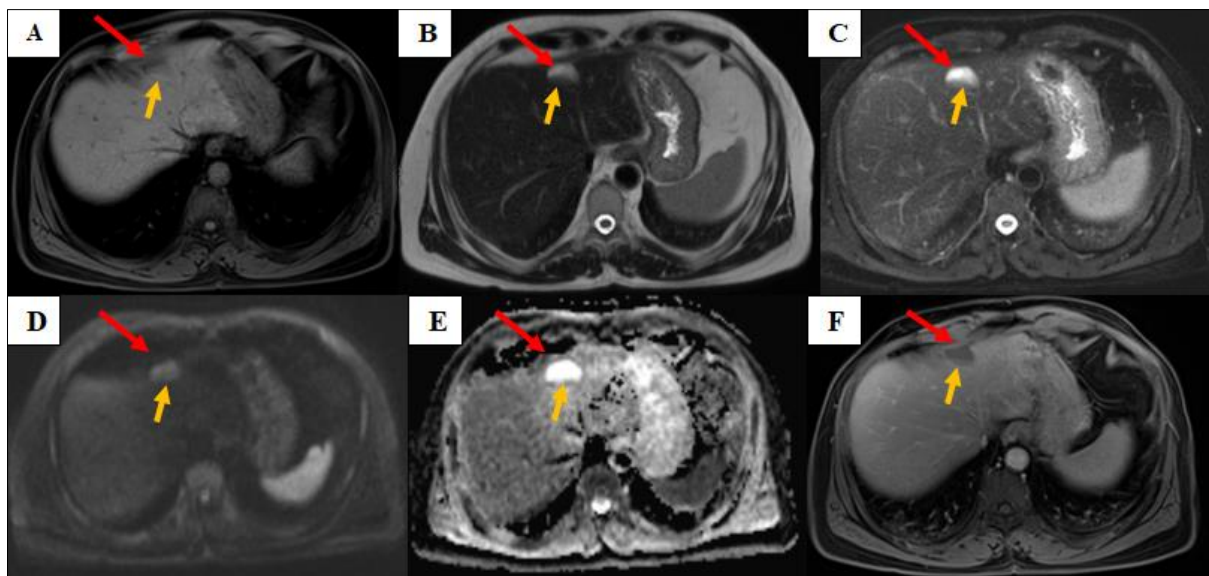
Axial MR images demonstrating a well-defined lesion (red arrows) hypointense on T1 (A), markedly hyperintense on T2 (B,C). It was the seat of a sediment creating a fluid-fluid level (yellow arrows) hyperintense on T1 (A) and hypointense on T2 (B,C). No diffusion restriction was demonstrated (D,E) and no significant enhancement was identified after gadolinium administration (F)
